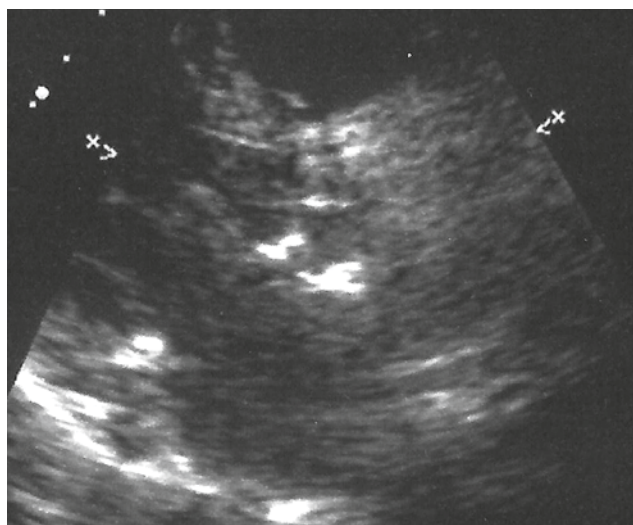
Postoperative echocardiogram – good decalcification effect (left parasternal short axis view at the aortic valve level)
